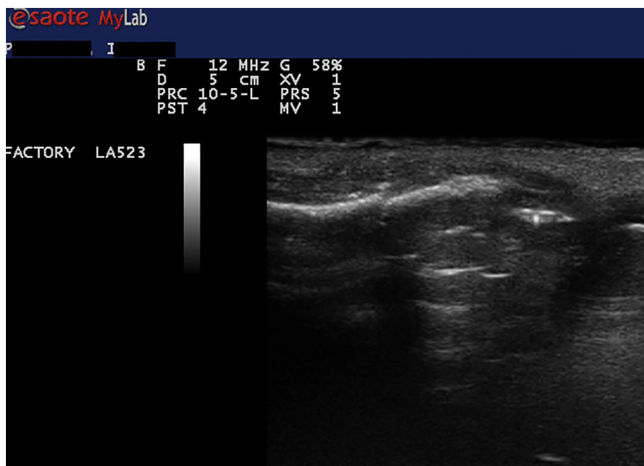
Ultrasonography images of nasal bone fracture.
